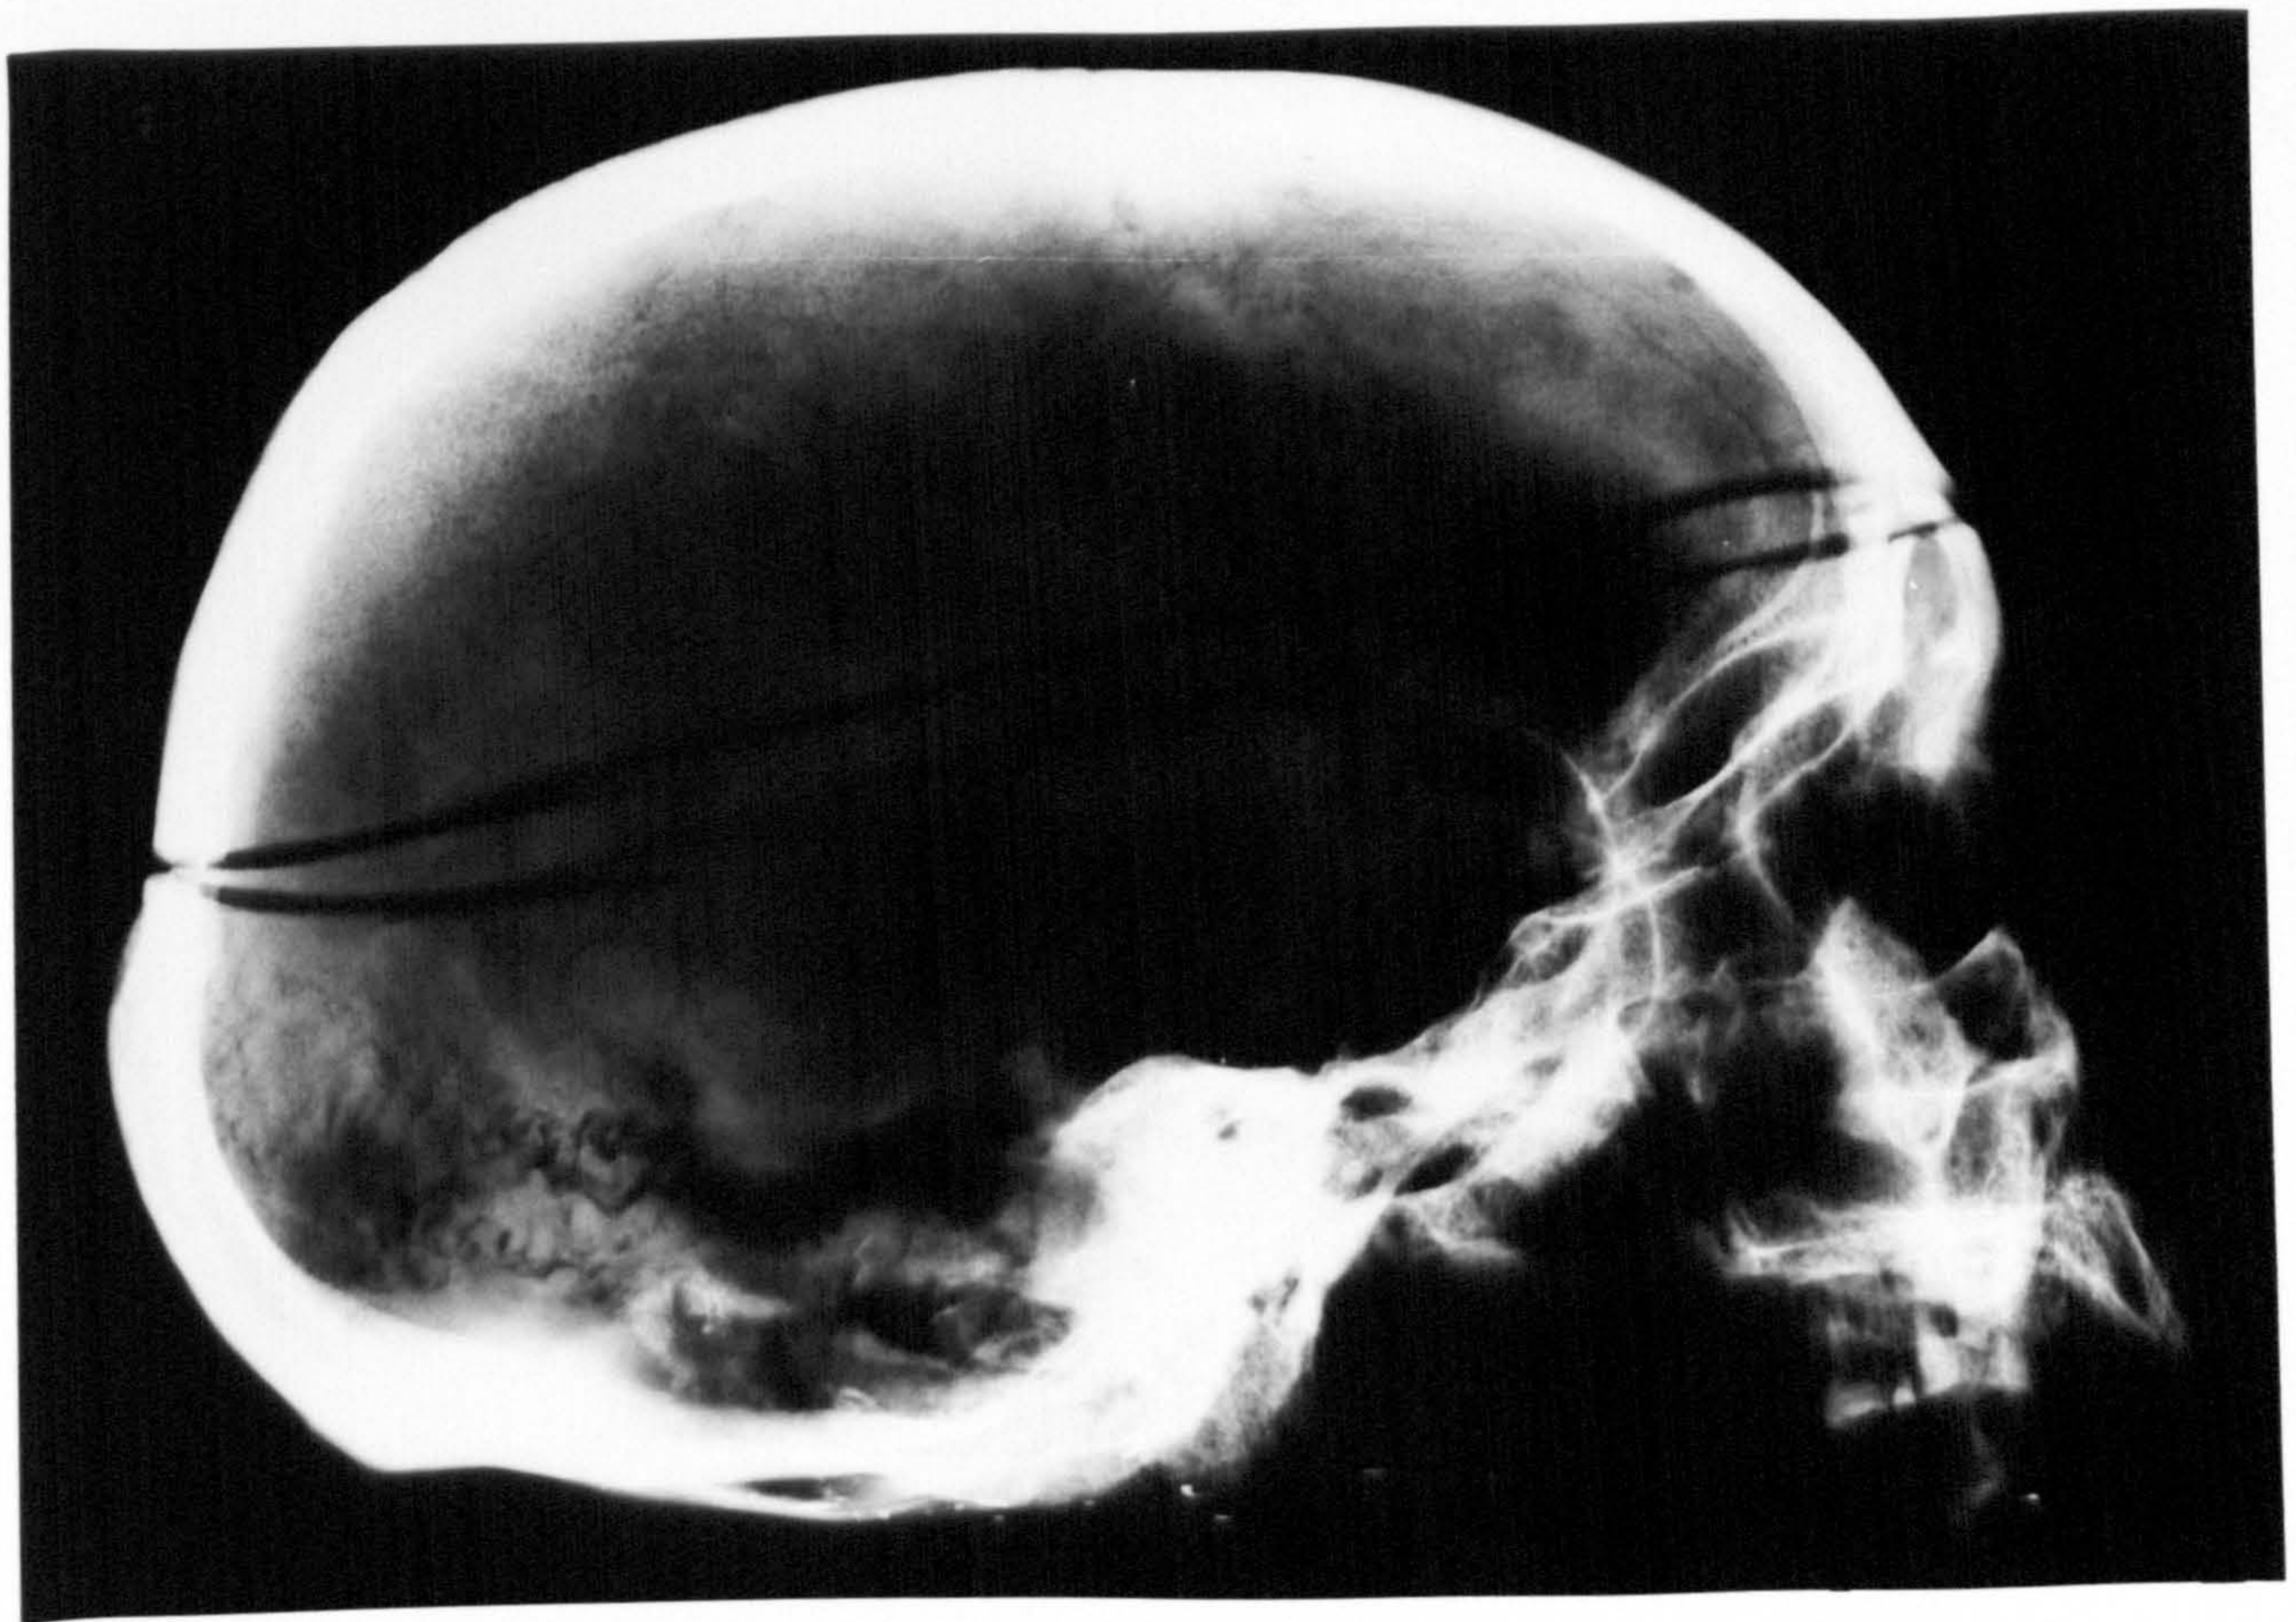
X-ray appearance and visual appearance of grade 0 HFI
